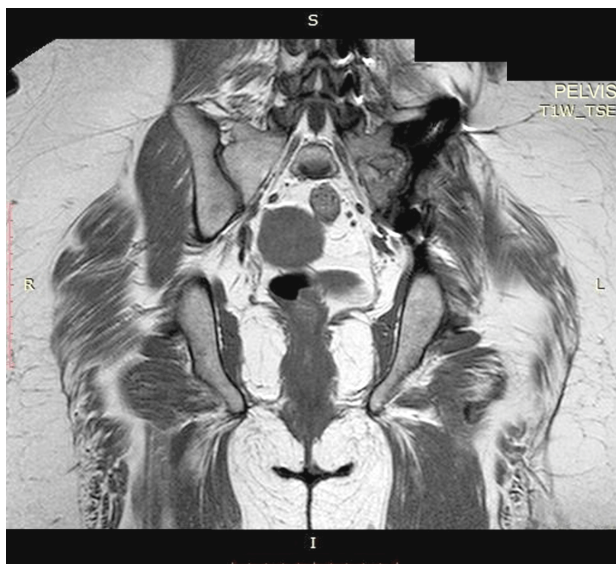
Two-year follow-up contrast-enhanced coronal T1W image of MRI. The postoperative area presents hypointense signal on T1W sequence. The postoperative area, situated in the proximity of the left conjugated foramina S1–S2, has polylubular appearance and dimensions 30/16/23 mm (CC/AP/T – Craniocaudal/Anteroposterior/Transversal). MRI: Magnetic resonance imaging; T1W: T1-weighted; TSE: Turbo spin echo.
